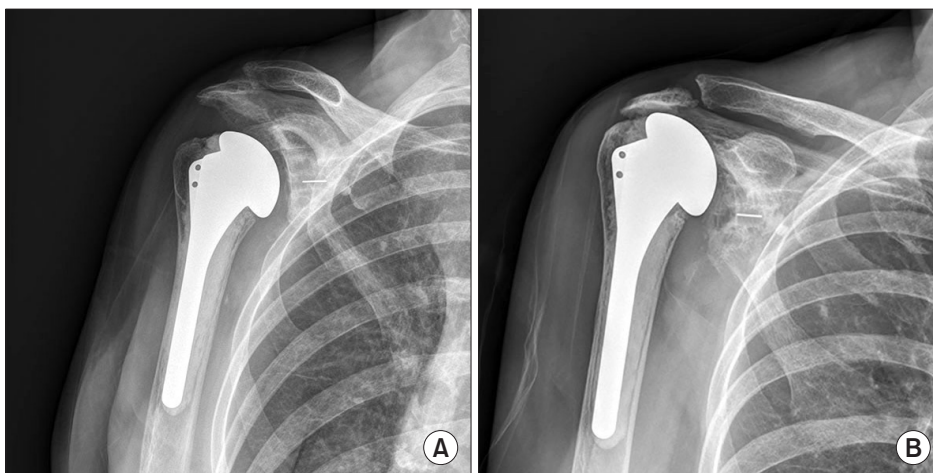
Total shoulder arthroplasty performed in a 67-year-old woman with rheumatoid arthritis. (A) Early postoperative radiograph. (B) Two-year postoperative radiograph demonstrating superior migration of the humeral head.
